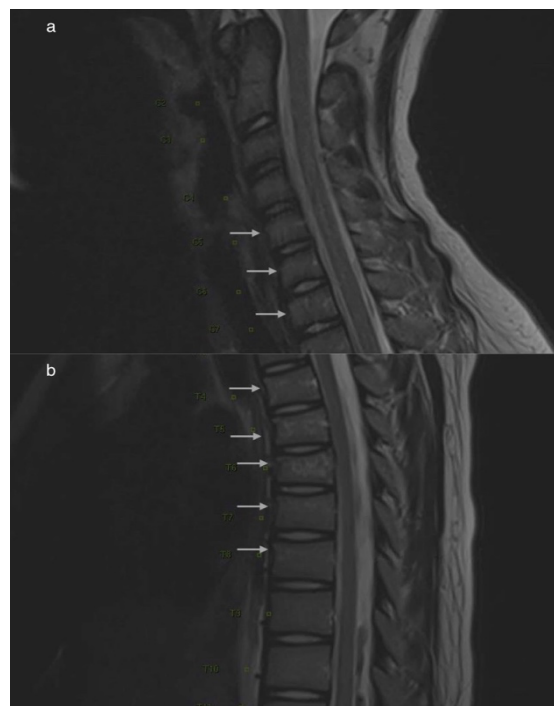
Sagittal T1-weighted magnetic resonance imaging of cervical and thoracic spine revealing multiple compression fractures involving C5-T1 vertebral bodies (a) and T4-T8 (b).
